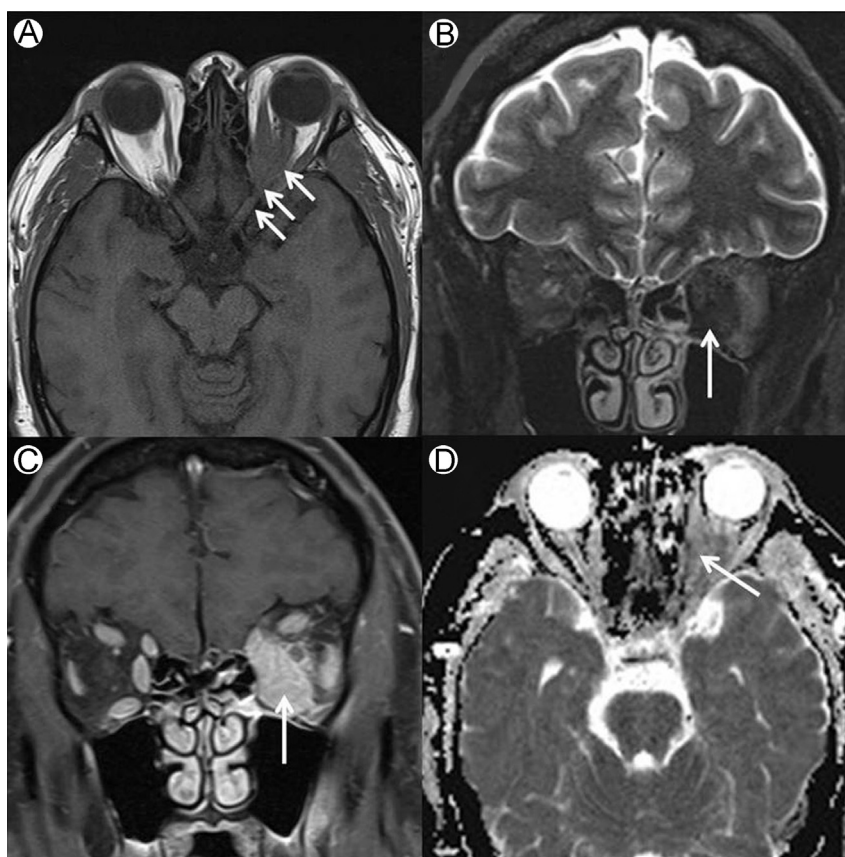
Compressive optic neuropathy (CON): (A) axial T1-weighted; (B) coronal STIR; (C) coronal T1-fat-saturation postcontrast; and (D) axial DWI images of a transpatial, solid enhancing lesion that shows diffusion restriction (arrows, B-D). The optic nerve is encased and compressed (arrows, A). Biopsy revealed diffuse large B cell lymphoma. DWI, diffusion-weighted imaging; STIR, short tau inversion recovery.
